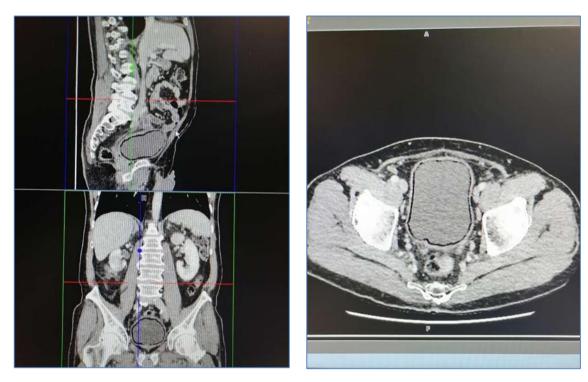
CT scan images demonstrating emphysematous cystitis
